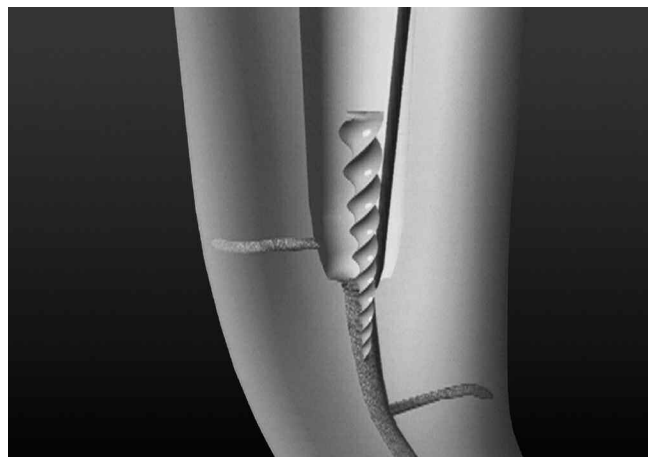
A graphic demonstrates the importance of coronal and radicular access, the staging platform and the ultrasonic instrument just lateral to the broken file.
